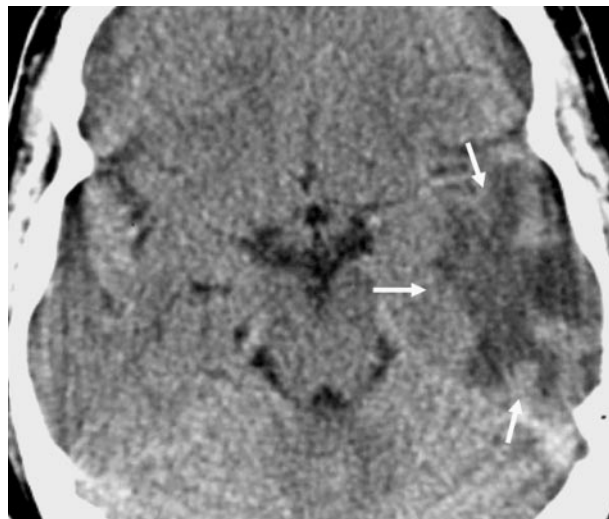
Axial unenhanced CT image obtained through the level of the midbrain shows left temporal lobe hypoattenuation (arrows), reflecting vasogenic edema, predominantly involving white matter.
